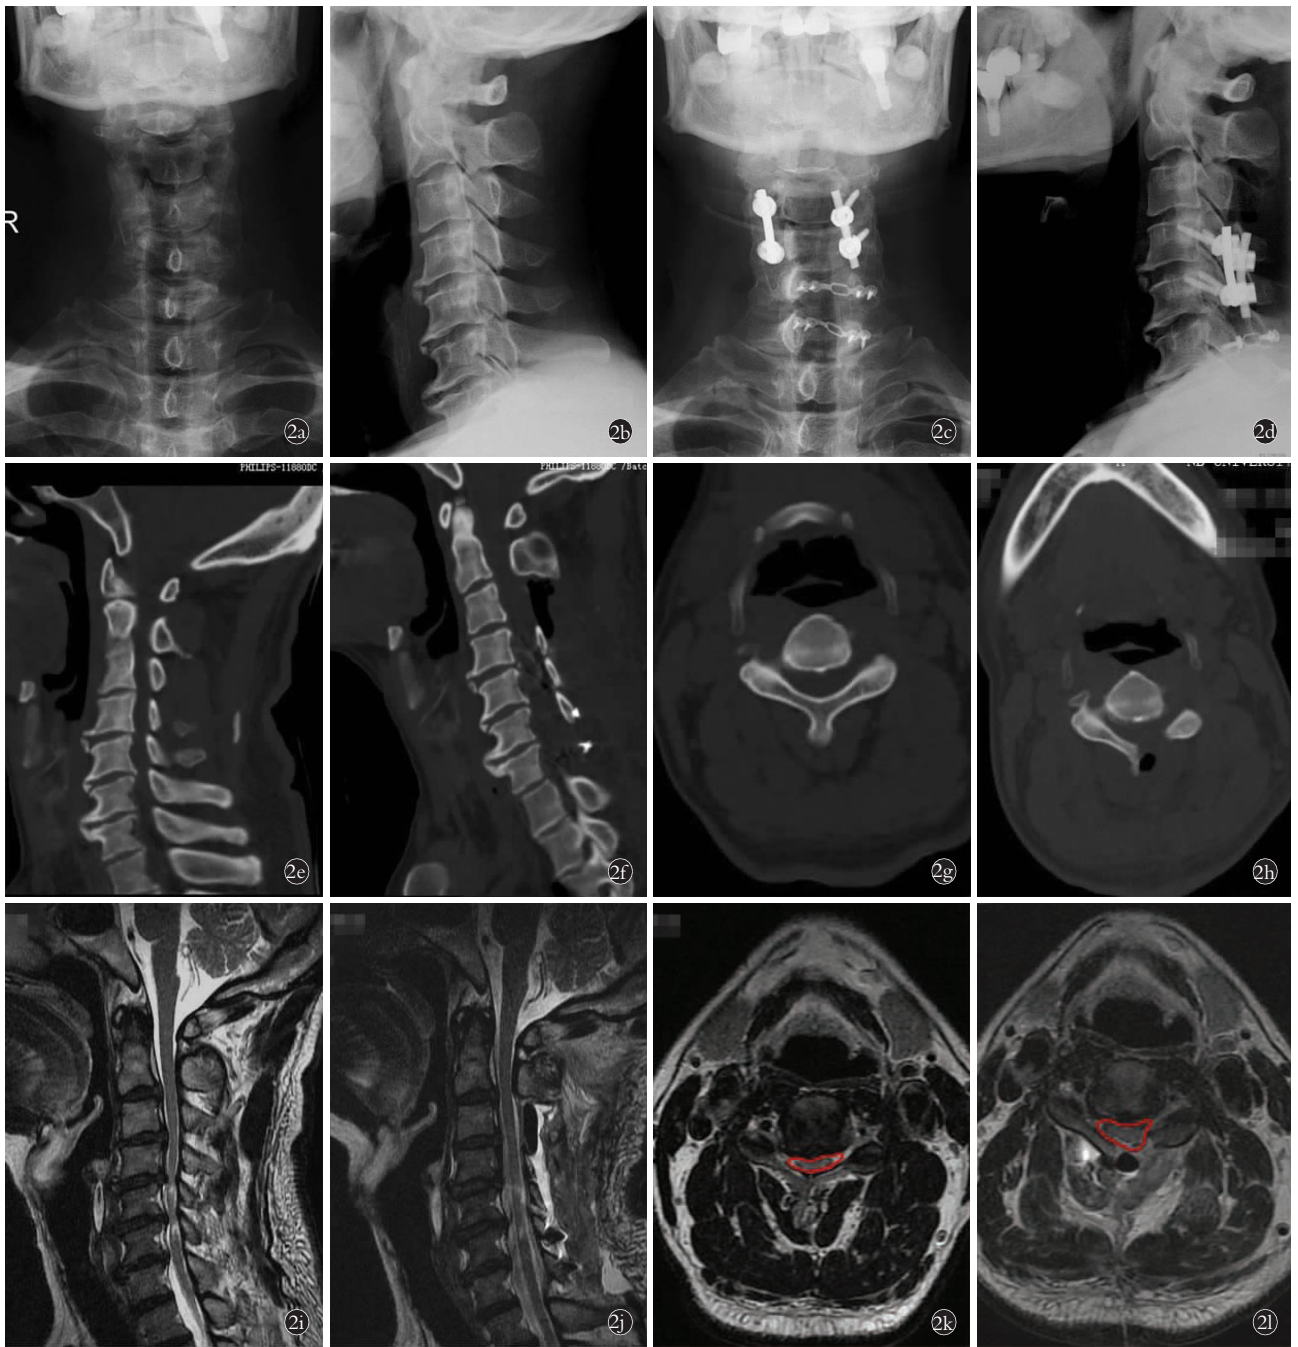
患者,男,61 岁,脊髓型颈椎病合并发育性颈椎管狭窄,行 C₃ 扩大半椎板切除单开门椎板成形术治疗 2a,2b. 术前颈椎正侧位 X 线片示颈椎增生、曲度变直 2c,2d. 术后 1 周颈椎正侧位 X 线片可见内固定影 2e, 2f. 术后 1 周颈椎 CT 矢状位重建示颈椎管较术前明显增大 2g,2h. 手术前后 C₃ 水平最狭窄处 CT 横断面平扫可见扩大半椎板切除后改变 2i. 术前 1 周颈椎 MRI 矢状位显示 C₃-C₇ 椎管狭窄,脊髓受压 2j. 术后 10 d 颈椎 MRI 矢状位显示颈脊髓减压良好 2k. 术前 1 周颈椎 MRI C₃ 水平最狭窄处横断面示椎管狭窄 2l. 术后 10 d 颈椎 MRI 示 C₃ 水平最狭窄处横断面可见椎管扩大
